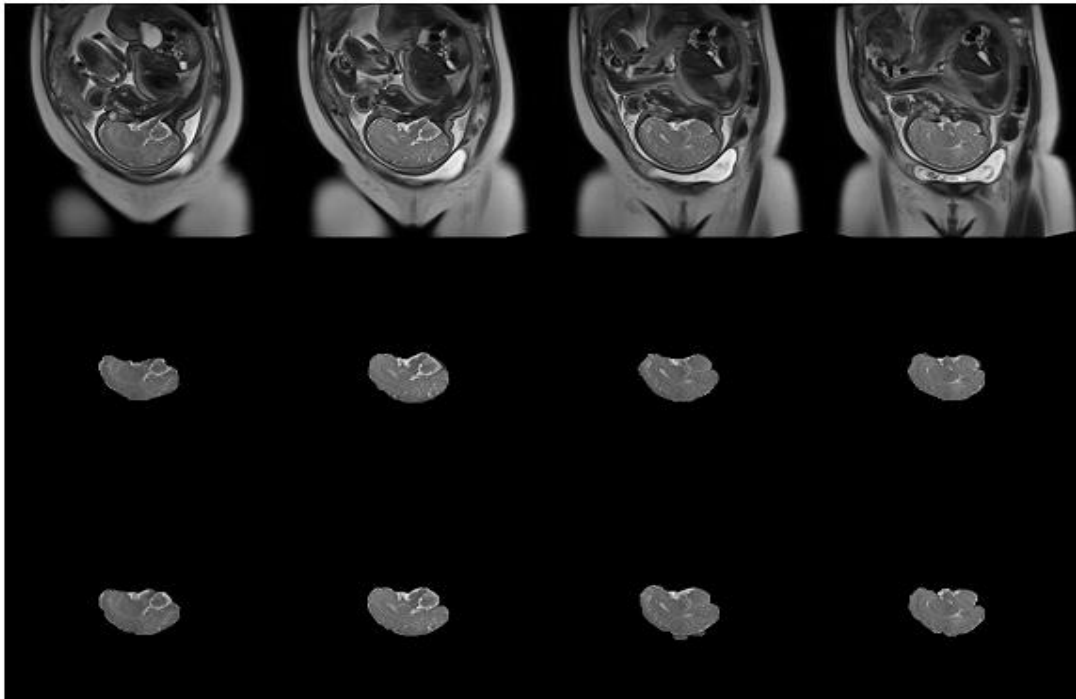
Sagittal view of a segmented fetal brain obtained via MRI scan. Row 1: original MRI images, row 2: manual Segmentation, row 3: proposed result.
